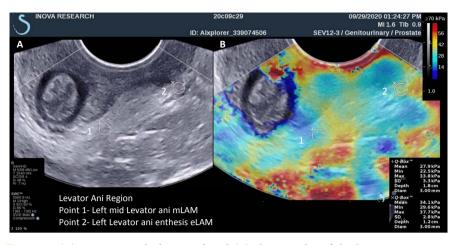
(A) Conventional ultrasound and (B) elastography of the levator ani region. Depth and elastography moduli from 2 measurement sites are displayed on the right side.
